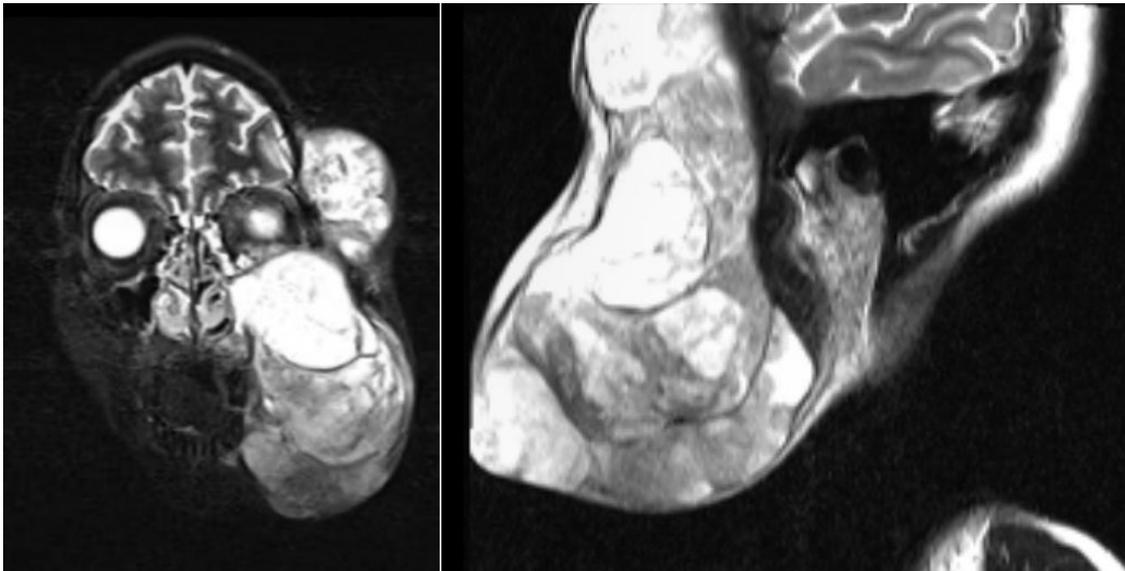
MRI gives us detailed information about the location, size, boundaries, and contents of the tumor. Low signal intensity on T1 weighted images, high signal intensity on T2 weighted images and marked enhancement after IV gadolinium.
